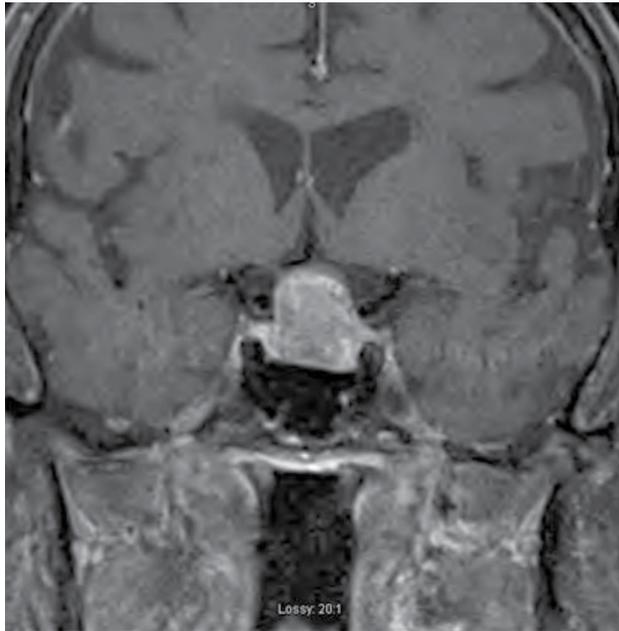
Coronal MRI of a patient with a small pituitary macroadenoma who presented with headache likely the result of stretching of the diaphragm sella.
